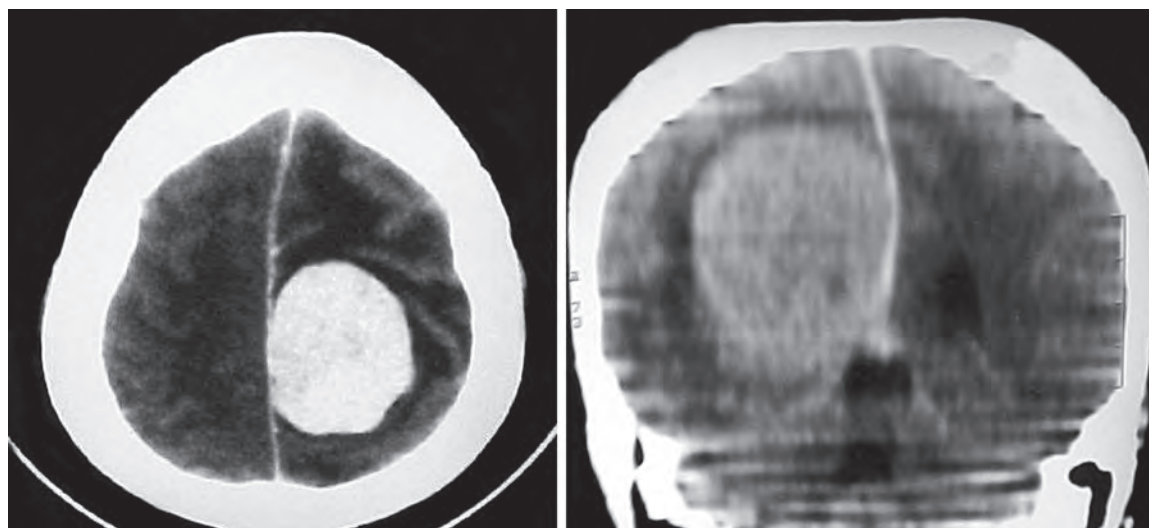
CT scan showing a middle-third falx meningioma
